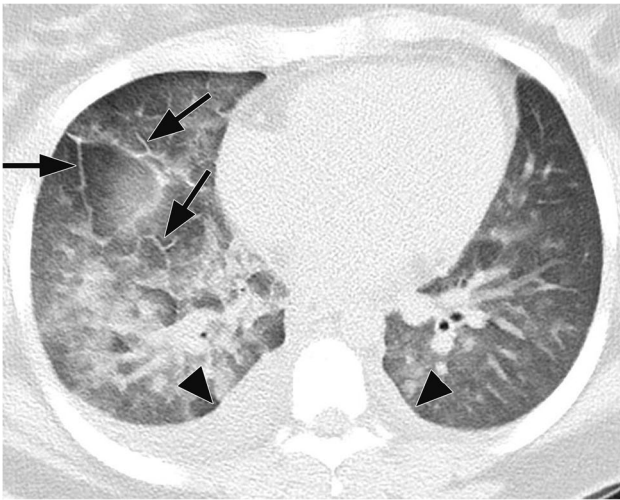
Chest CT findings in an 18-year-old woman with multisystem inflammatory syndrome in children (MIS-C) who presented with fever and hypoxia. Axial chest CT in lung window demonstrates pulmonary edema with ground-glass opacities, interlobular septal thickening (arrows) and small pleural effusions (arrowheads)
